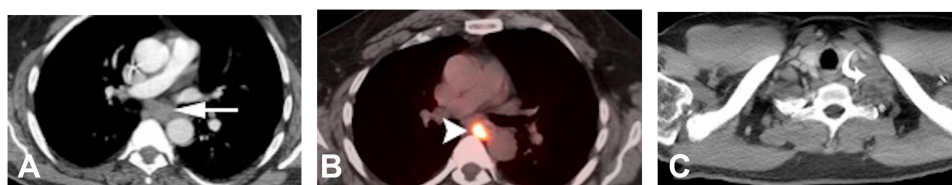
Distant lymph-node metastases. (A) Chest CT soft-tissue window showing subcarinal mediastinal lymphadenopathy with corresponding PET-CT. (B) Increased FDG avidity. (C) Left supraclavicular lymphadenopathy in axial CT with soft-tissue window settings.
